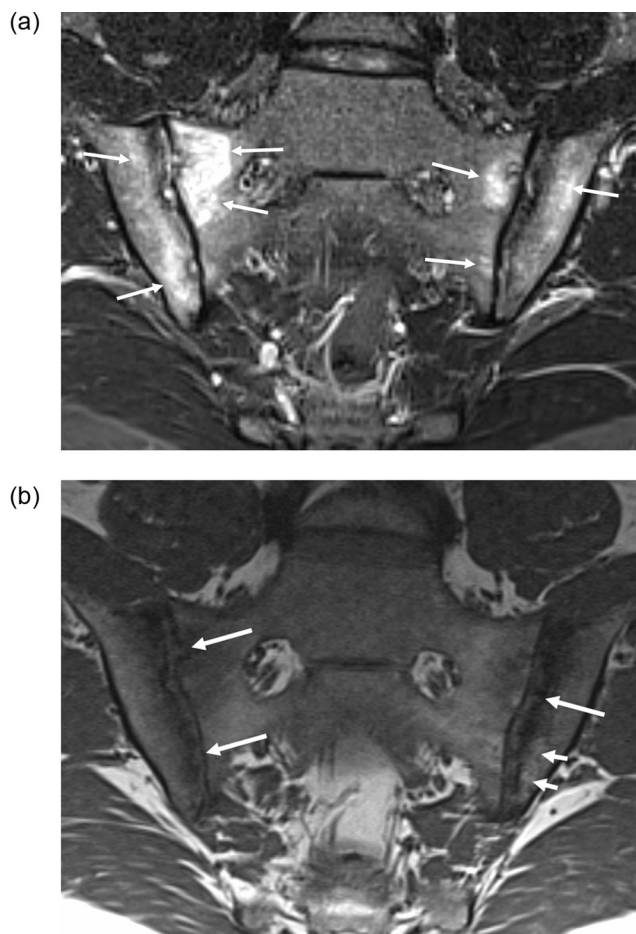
BMO of the SI joint in spondyloarthritis. (a) Semicoronal STIR MR image shows bilateral extensive BMO of the SI joint (arrows). (b) Semicoronal T1-weighted MR image shows bilateral erosions (arrows) and minimal fat infiltration of the left SI joint (short arrow).
